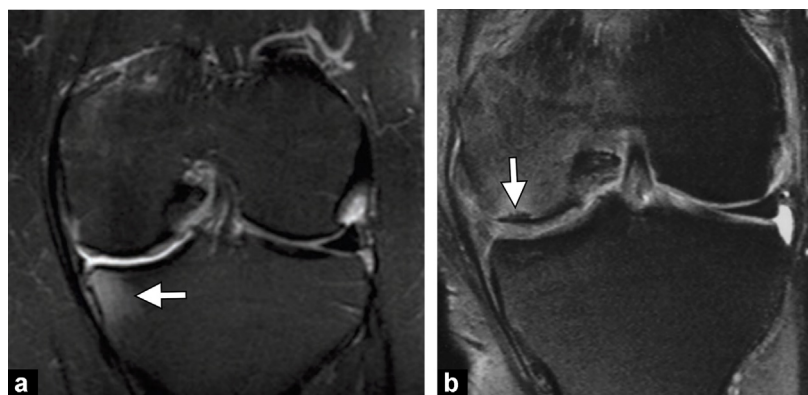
Modification of subchondral bone after meniscectomy: a: coronal fat-suppressed PD-weighted MR image. Bone edema-like high signal intensity (arrow) 1 month after medial meniscectomy indicating mechanical adaptation; b: coronal fat-suppressed PD-weighted sequence in another MR image. Mechanical osteonecrosis following partial medial meniscectomy (arrow).
